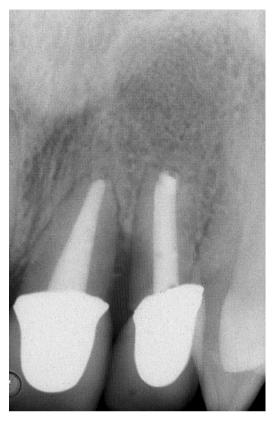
Significant bone loss is evident radiographically between the fractured central incisor and the adjacent lateral incisor.
